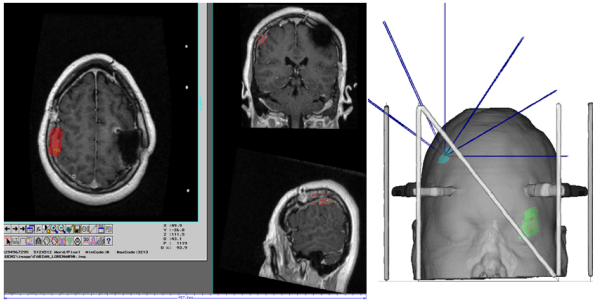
T1 Gd-enhanced MRI revealing a left parietal lesion 2 cm in diameter.
